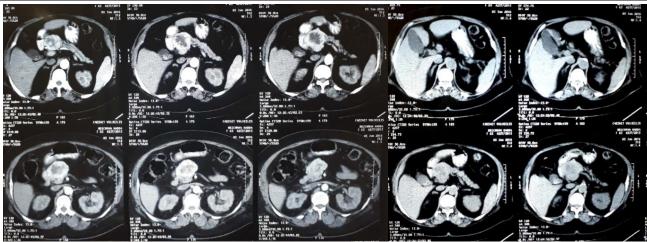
CT image showing a mass of the necrotic head of the pancreas without dilation of the bile ducts and Wirsung
